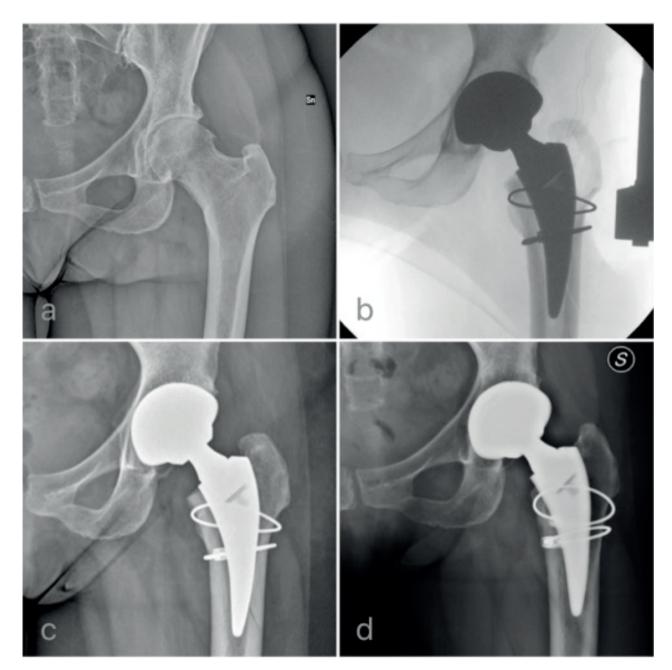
Clinical case of periprosthetic intraoperative fracture with DAA. (a) Preoperative x-ray; (b) intraoperative x-ray showing the fracture treated with cerclage wiring; (c, d) postoperative x-ray images at 1 and 6 months in which healing of the periprosthetic fracture is showed
